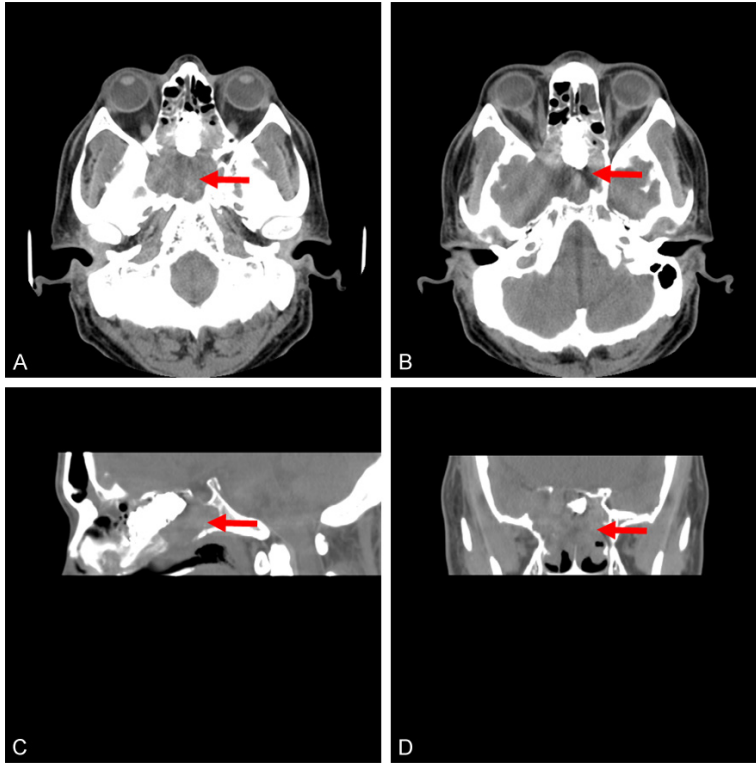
The pre-operative CT scans of the patient. (A, B) Axial, (C) Sagittal, and (D) coronal computed tomograms demonstrate a mass (red arrows) located in the sphenoid sinus that is invading the cavernous sinus, optic canal, and posterior ethmoid sinuses, causing reactive hyperostosis.
